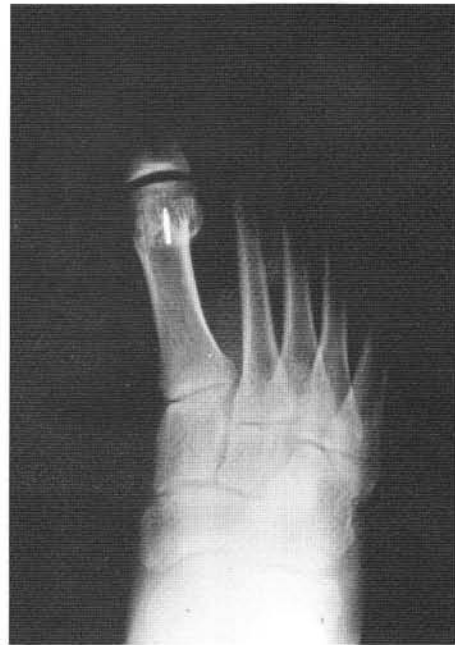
Postoperative DP weight-bearing radiograph with 0.062" threaded K-wire.
